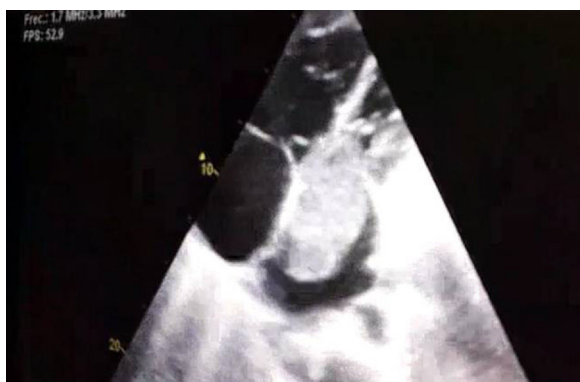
Echocardiography showing a large mass in the left atrium (6.3×3.2 cm) in diastole protruding into the left ventricle.
